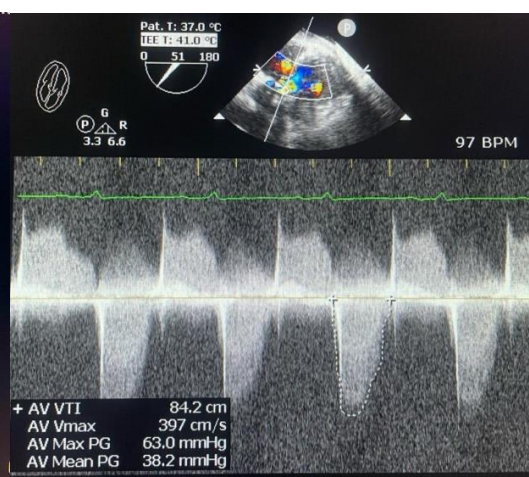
TEE deep transgastric view pulse wave doppler showing gradient across aortic valve s/o Severe Aortic stenosis.
